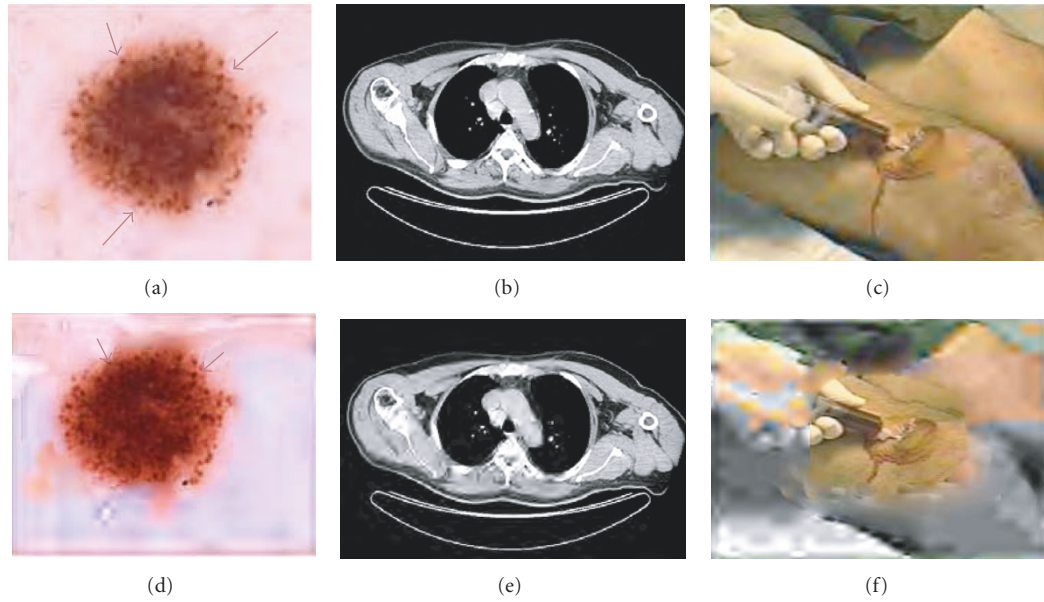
Image samples compressed at different scaling factors and region of interest (ROI) coding. (a) Skin lesion image, (b) MRI image, and (c) medical video image (snapshot) compressed at 0.5 scale factor, respectively. (d)–(f) The same images with background compressed at 0.1 scale factor and ROI at 0.5.
